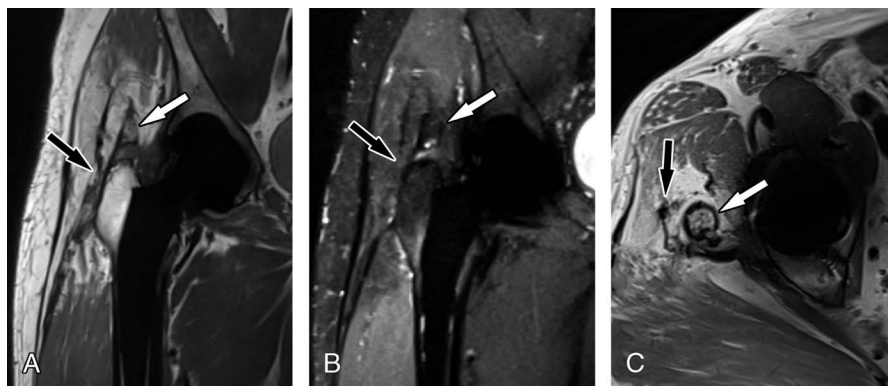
A 47-year-old man with lateral hip pain after right hip arthroplasty. Three-Tesla metal artifact reduction MRI of right hip arthroplasty implants using 8-fold compressed sensing–accelerated coronal proton density–weighted (A), coronal STIR (B), and axial proton density–weighted (C) SEMAC TSE pulse sequences show high-grade partial-thickness tearing the lateral footprint of the gluteus medius with chronically scar-remodeled and thinned tendon (black arrows), atrophy of the abductor muscle bulk, and mature heterotopic bone formation (white arrows). The MRI scans were obtained with a commercial 3.0-T MRI system (slow rate, 200 T/m/s; gradient strength, 60 mT/m) and 18 receiver channel surface and spine coil arrays.
